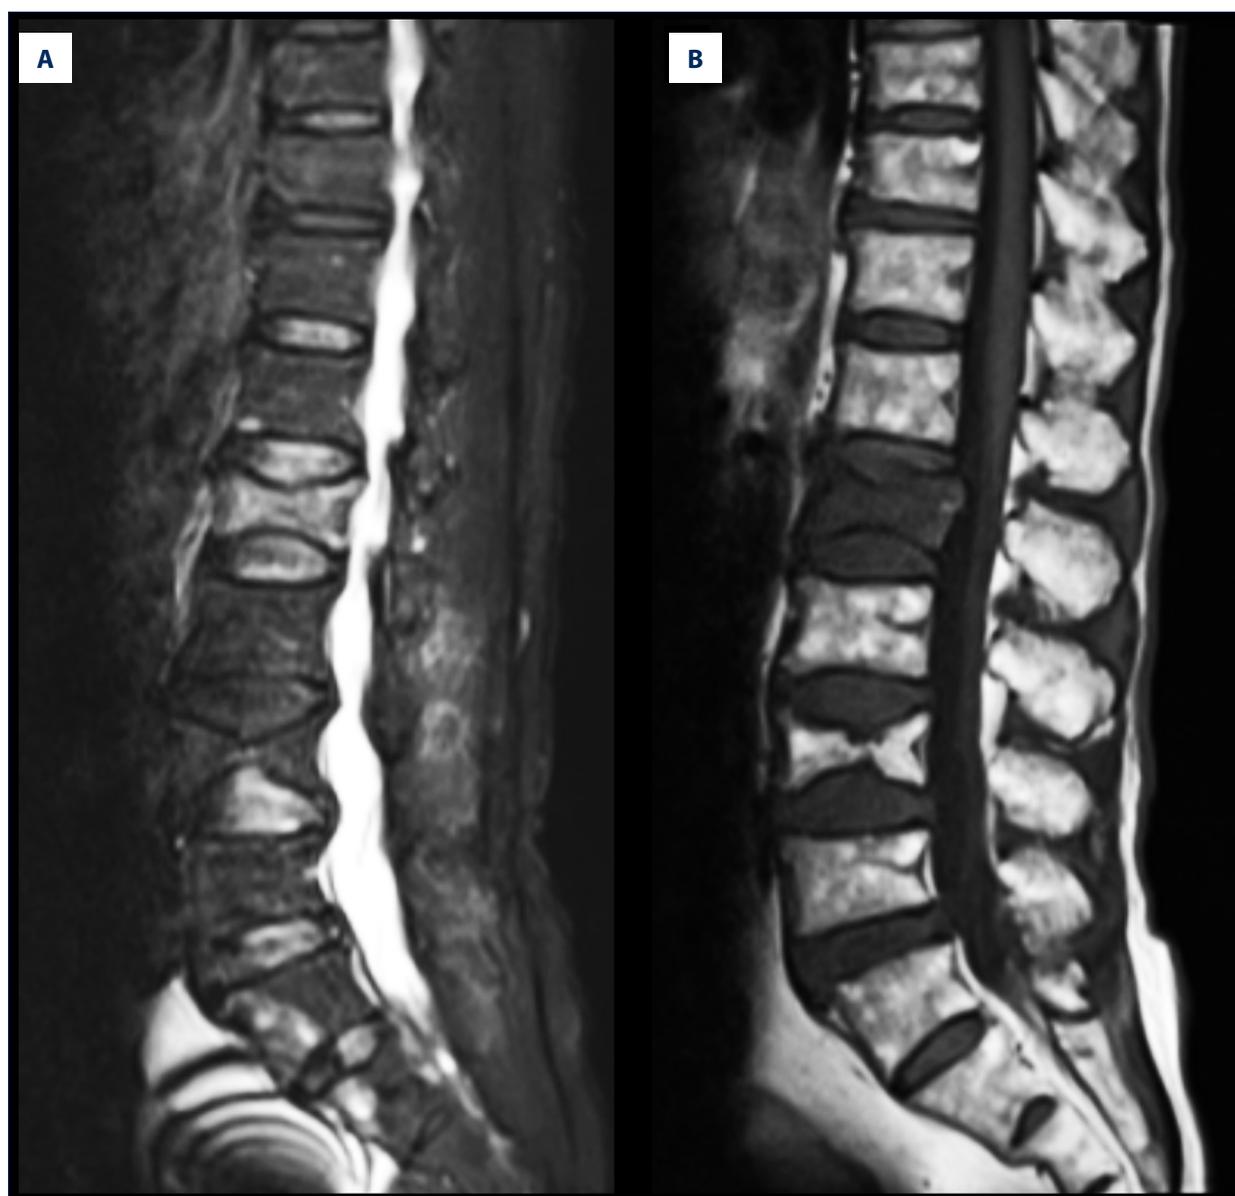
MR images of a representative case with traumatic lumbar before surgery. (A, B) Female, 85 years old, with no obvious traumatic lumbar symptom, but the patient has been in pain for half a month.
